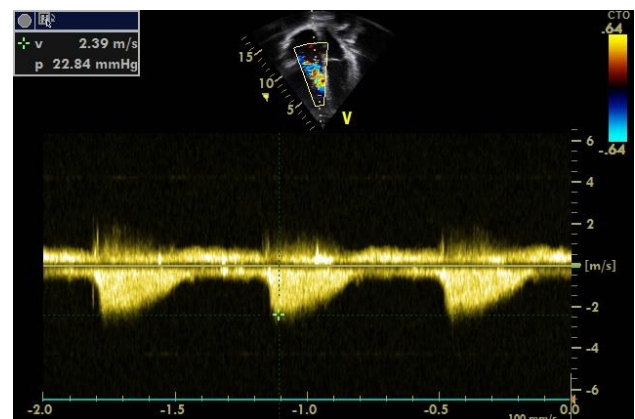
Echocardiography: Continuous wave Doppler. Low pressure TR. P (peak gradient) = 22.84 mmHg.
